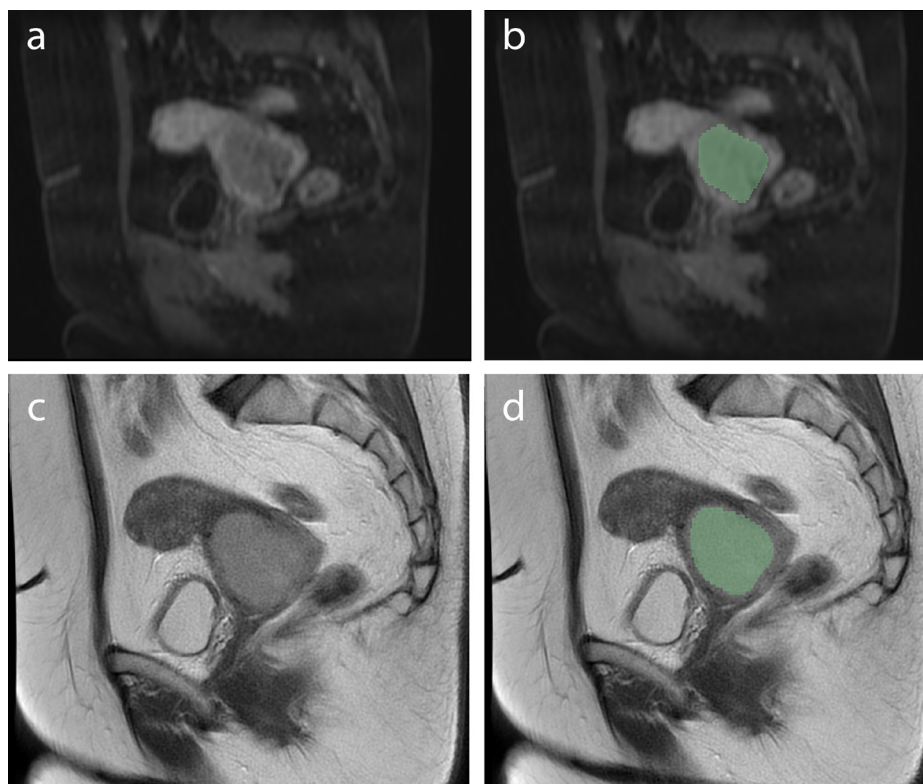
The segmentation process from contrast-enhanced T1-weighted images (a-b) and T2-weighted images (c-d).
